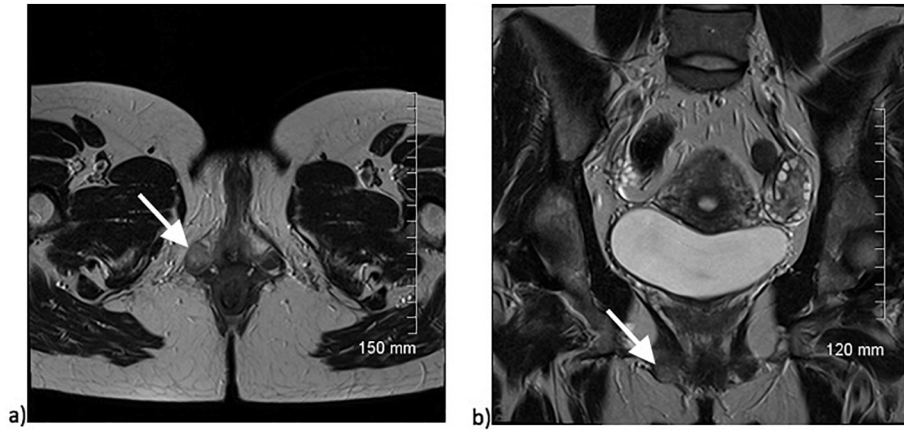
Axial (1) and coronal (b) T2-weighted images demonstrate mild asymmetric enlargement and subtle hyperintense signal in the right Bartholin's gland (arrows).
